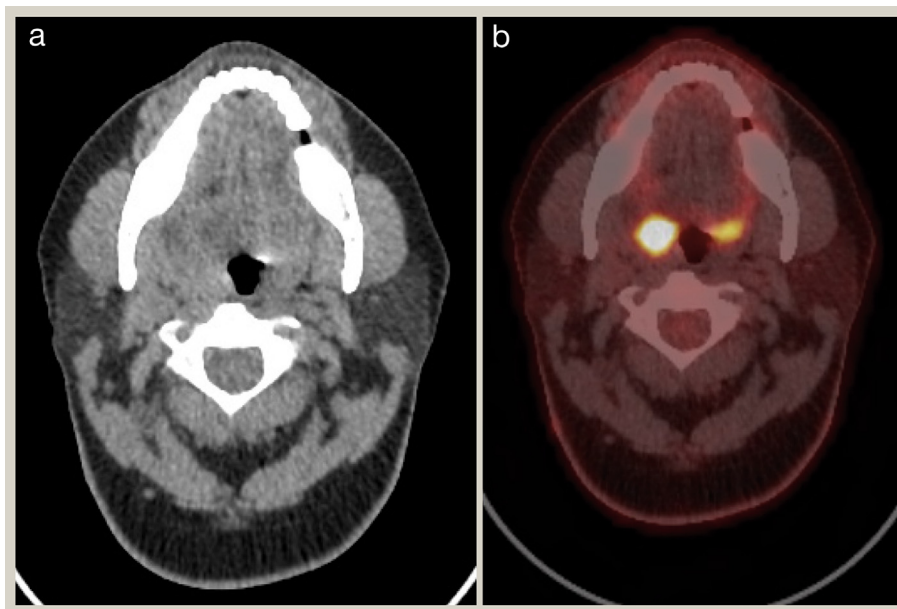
CT and PET CT scan showing a right tonsillar tumour. The tumour is not obvious on the CT scan, but lights up with clear asymmetry on the PET-CT scan.
